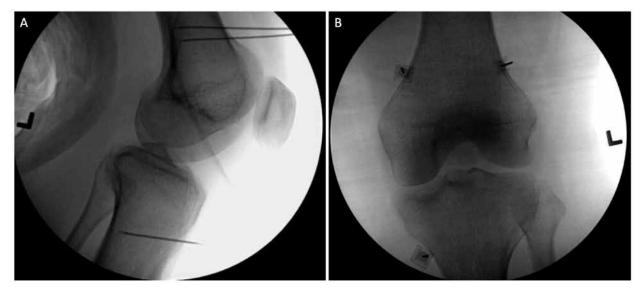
Lateral (A) and anteroposterior (B) views of second genicular nerve radiofrequency ablation. Probes were driven to predetermined positions informed by MRI mapping of the genicular neurovascular bundles.
